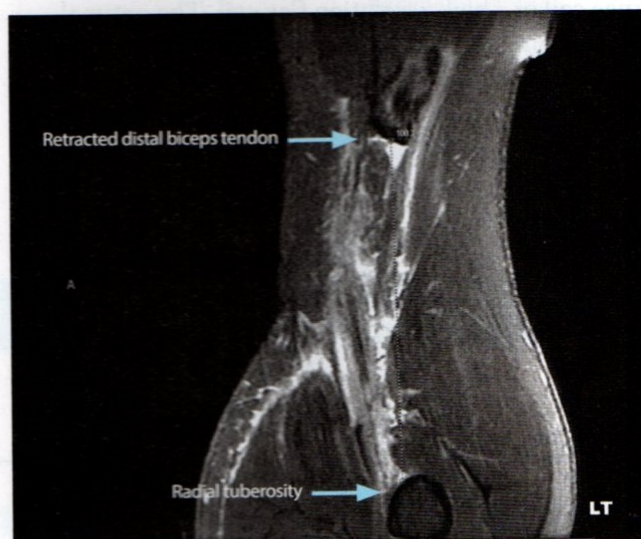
MR image showing the utility of the DOC technique for diagnosing a distal biceps tendon attachment that is torn and retracted from the radial tuberosity. Image courtesy of the authors.
